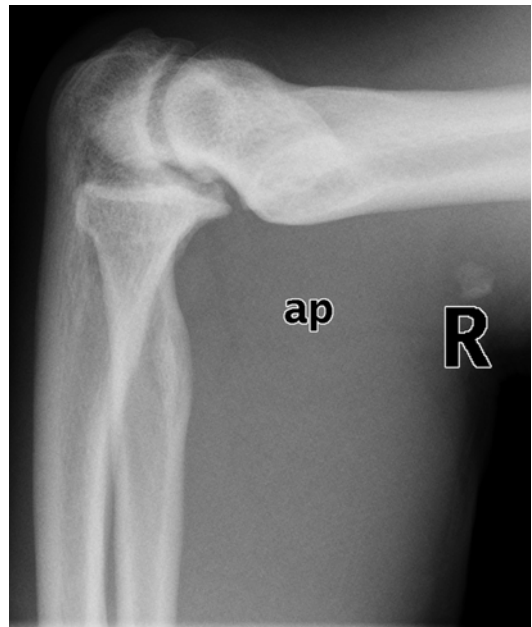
Preoperative lateral x-ray of a young male with malunion 2 years after a supracondylar humeral fracture treated insufficiently with k-wire fixation. The patient had at presentation pain and a ROM of -20 – 85° . This patient was treated with open osteotomy and release and obtained ROM of 5 – 125°
